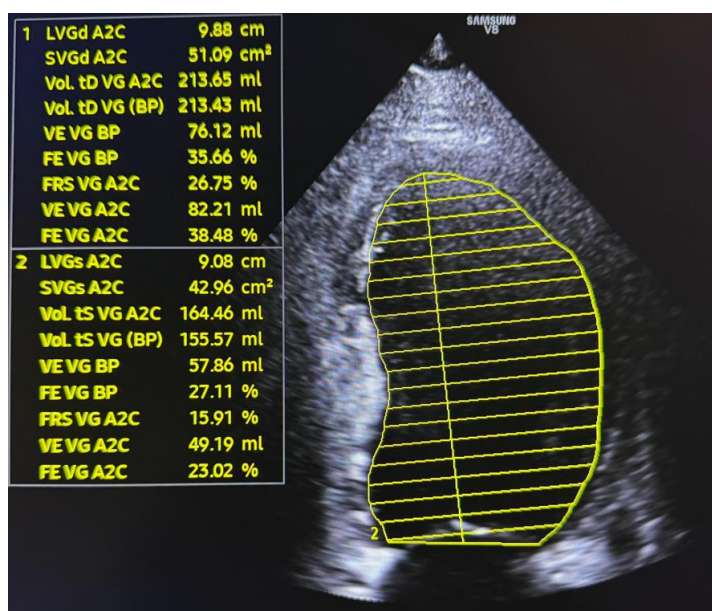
Echocardiography showed reduced LVEF
